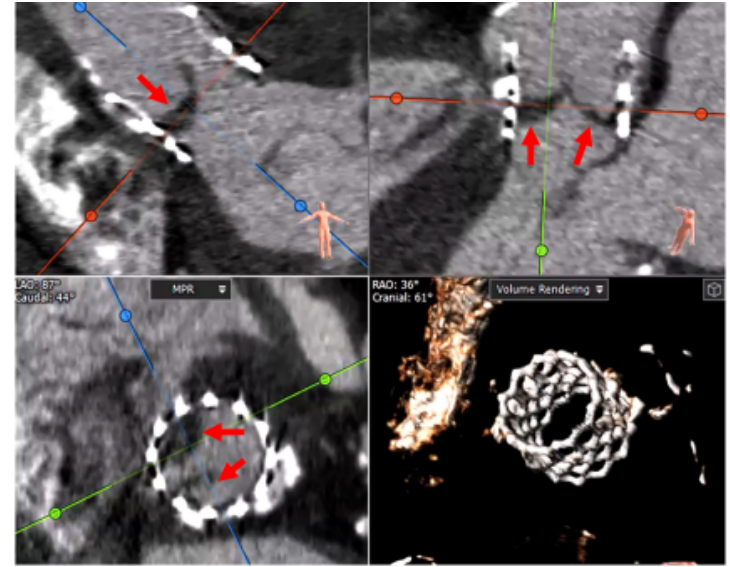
Typical 4D-CT appearance of bioprosthetic thrombosis. This patient presented with an acute myocardial infarction 9 months after transcatheter aortic valve replacement with a 26 mm Sapient 3 prosthesis. An elevated prosthetic gradient was suspicious for valve thrombosis. The image shows thickened leaflets (arrows), as well as reduced leaflet motion (Movie 2).
